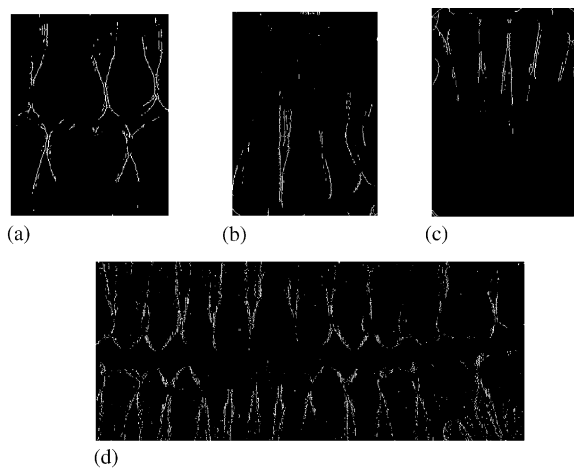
Vertical edges in the three types of dental images: (a) bitewing; (b) upper periapical; (c) lower periapical; (d) panoramic.
